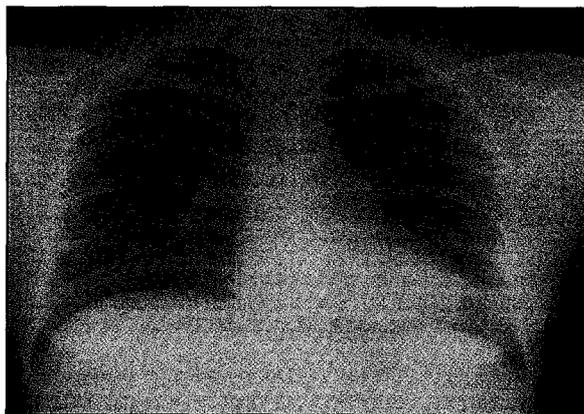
Chest radiograph performed after 3 cycles of ABVD chemotherapy
